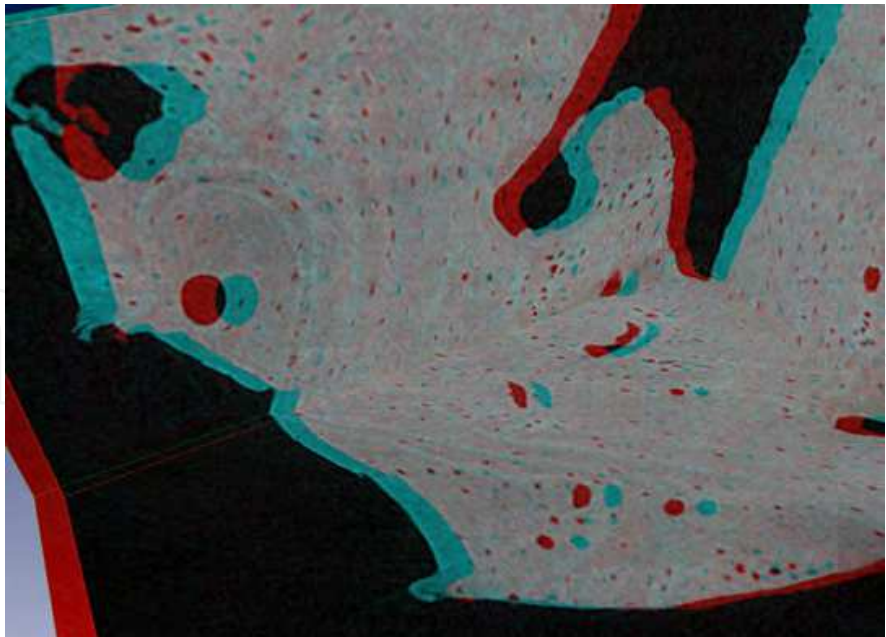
Stereoscopic view of the projection from the healthy bone biopsy showing the osteocytes aligned along to the cement lines (SR-CT measurements @2.174  $\mu\text{m}$ ).
